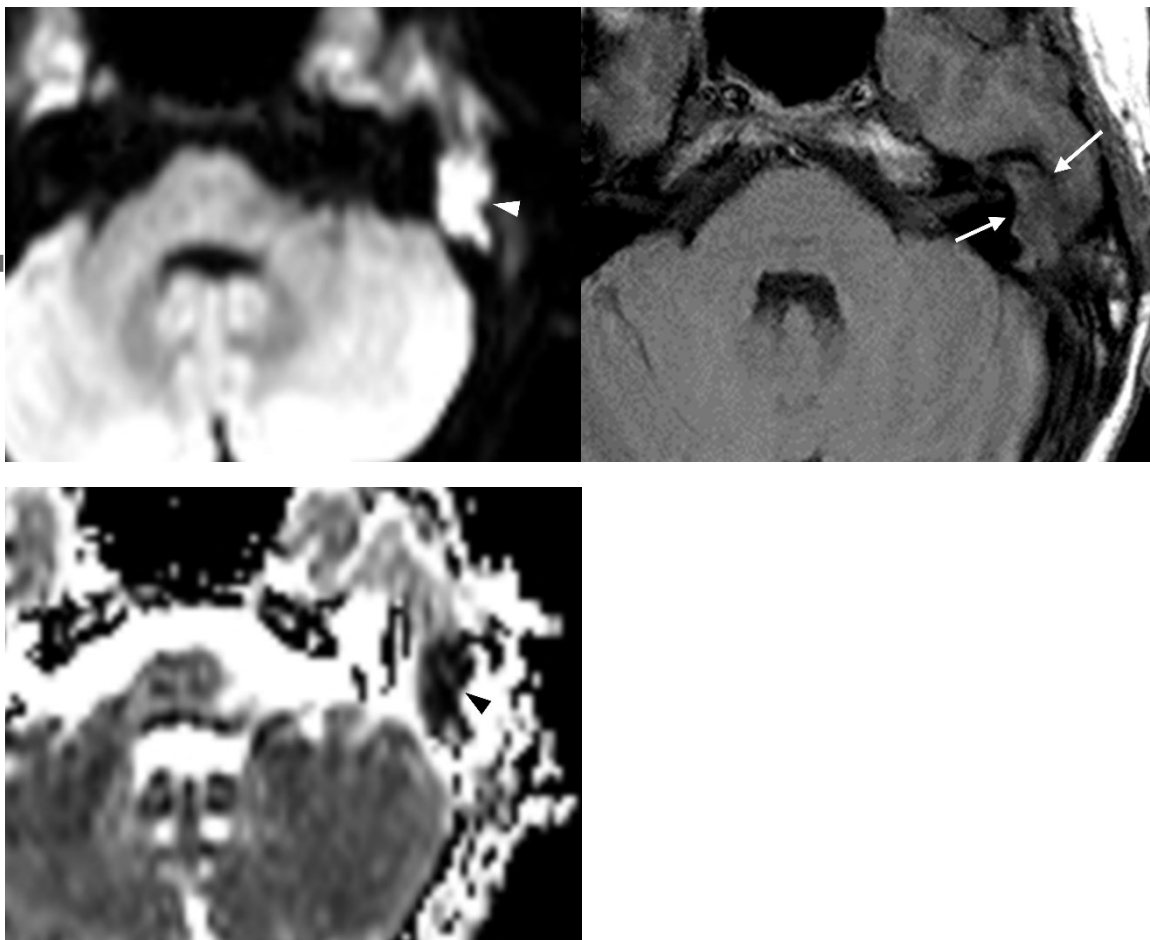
12-year-old male with a cholesteatoma of the left middle ear. On preoperative evaluation, the left mastoid shows partial low signal intensity on T1-weighted image (A, arrows) and high signal intensity on diffusion-weighted imaging (B, arrowhead), indicating mastoid extension of the cholesteatoma. Surgery revealed the mastoid extension. The apparent diffusion coefficient value of the lesion is very low ($0.58 \times 10^{-3} \text{mm}^2/\text{s}$) (C, arrowhead). The disease recurred three years after surgery.
